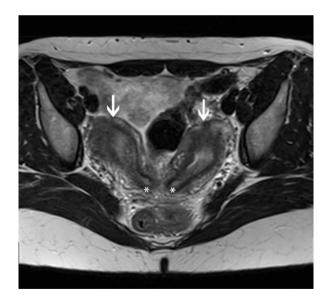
Septate uterus. Axial T2-weighted MR shows a prominent septation (asterisk) with separation of the uterine cavities extending through the cervix
